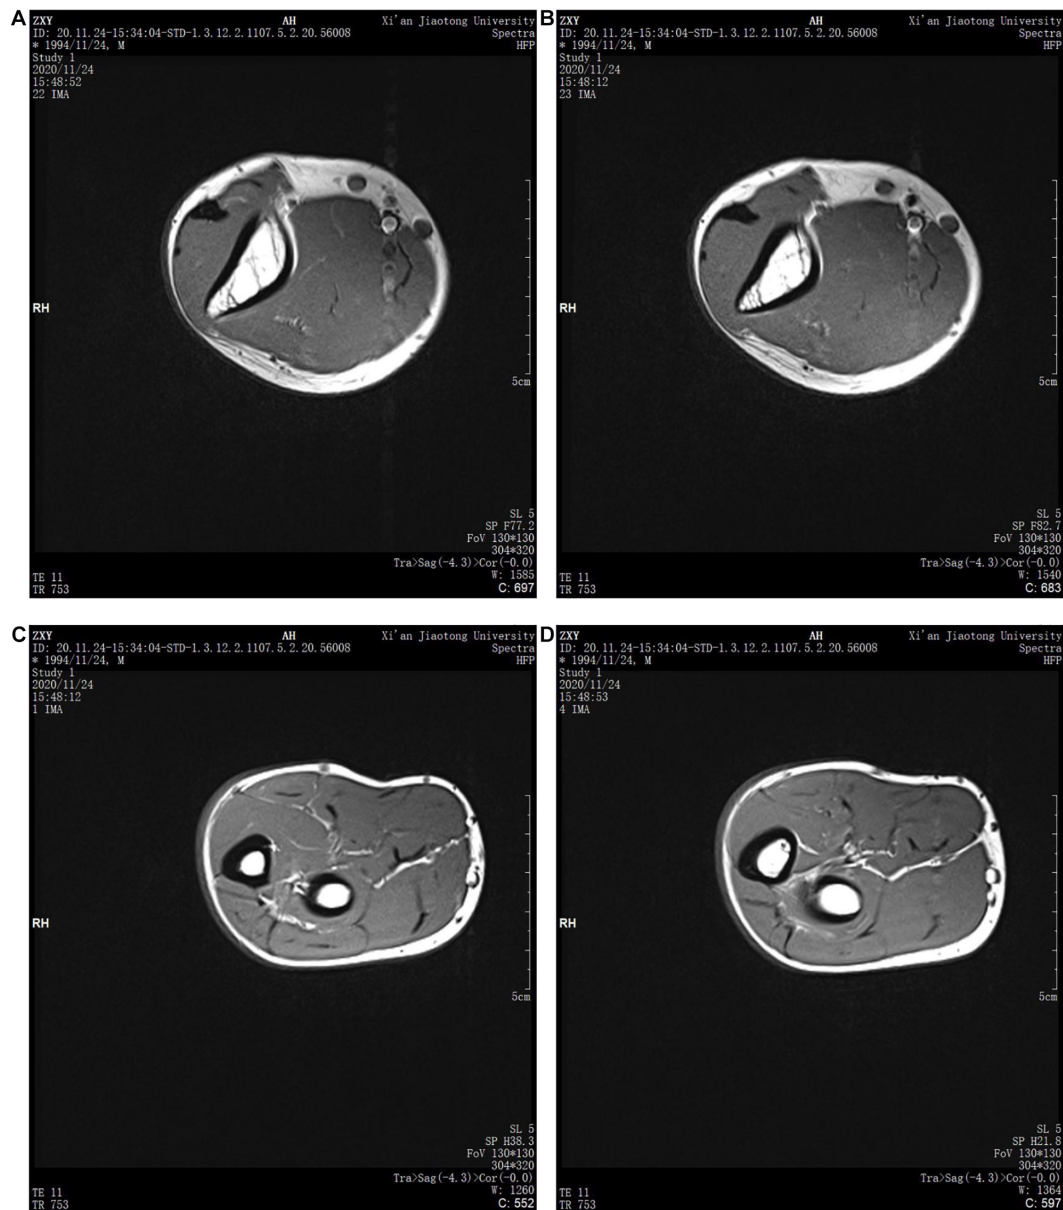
MRI images of human upper limbs: (A) upper arm scan Figure 1, (B) upper arm scan Figure 2, (C) forearm scan Figure 1, and (D) forearm scan Figure 2.
